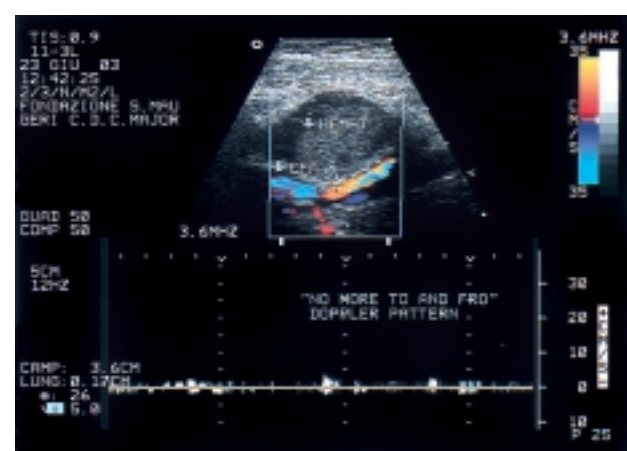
CFA = common femoral artery; HEMAT = hematoma substituting the pseudoaneurysm cavity in case of successful ultrasound-guided repair; TO AND FRO = pulsed Doppler pattern registered in the neck leading to the pseudoaneurysm.
